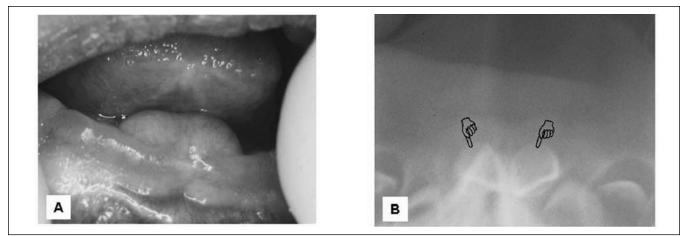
(A) Clinical aspect of the fluctuant, compressive and pink-colored lesion presented on the mandibular gingival ridge of a neonate and (B) radiographic aspects of the related area. The radiographic image shows the superficial positioning of the primary mandibular central incisors (pointers).
